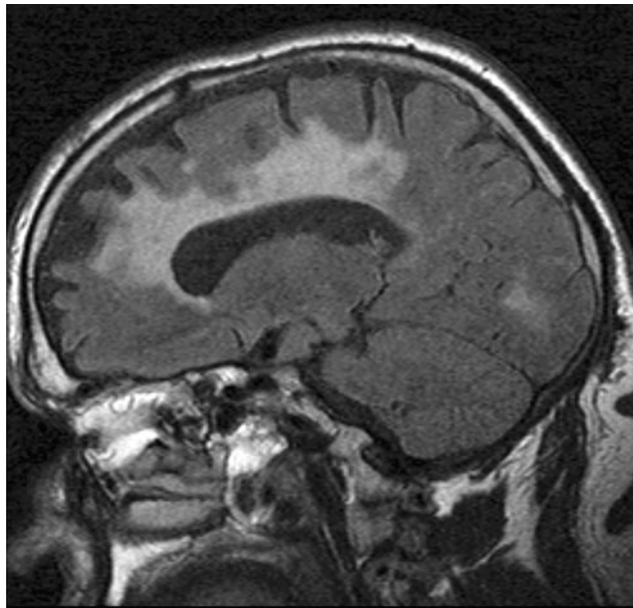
Magnetic resonance imaging fluid attenuation recovery sagittal image demonstrating significant periventricular white matter hyperintensity oriented perpendicular to the long axis of the lateral ventricle and extending through the deep white matter into subcortical areas. There is also greater than expected sulcal widening consistent with mild atrophy.
